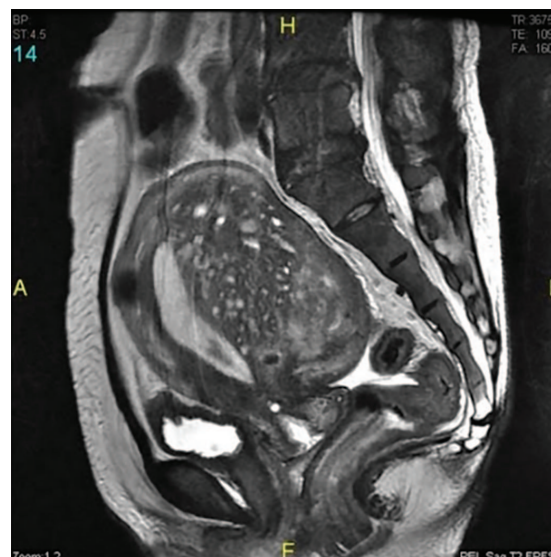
Sagittal T2-weighted MRI of adenomyosis uterus showing asymmetric thickening of uterine wall and myometrial cysts
